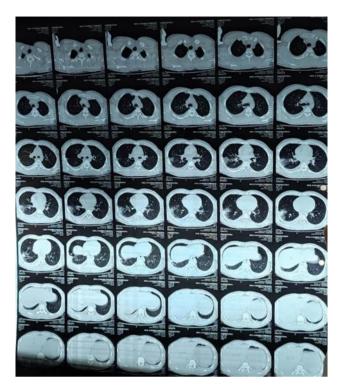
HRCT showing areas of haemothorax on the right side
